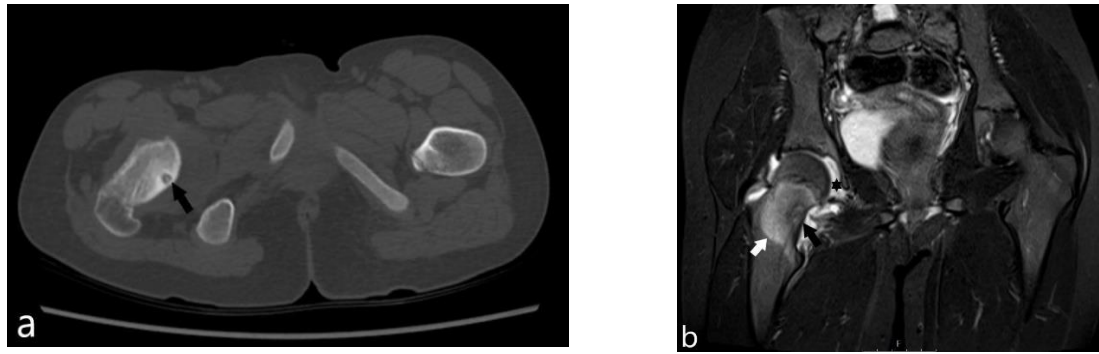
Intraarticular osteoid osteoma. 11 years old girl. CT (a). Calcified nidus located in the right femoral neck (arrow). Coronal T2 weighted suppressed MRI (b). The tumor nidus (arrow) is seen on MR imaging only as a subtle abnormality. Bone marrow edema (white arrow) and joint effusion (asterisk).
